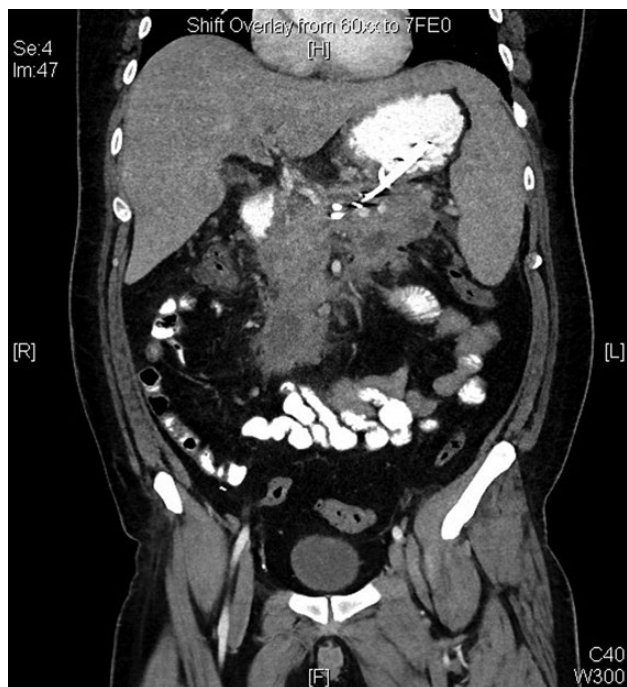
Undrained mesenteric abscess after endoscopic debridement. A 50-year-old man underwent uncomplicated endoscopic debridement for symptomatic walled-off pancreatic necrosis. He represented with fevers, pain, leukocytosis, and a phlegmonous abscess tracking down into the small bowel mesentery. Endoscopic debridement and CT-guided drainage were not felt to be possible. Surgical debridement was required.
